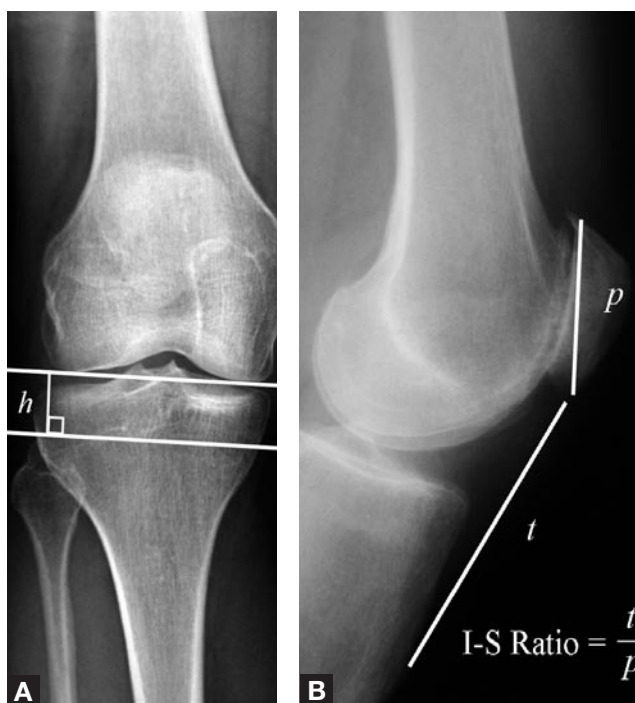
(A) Standing anteroposterior x-ray shows joint-line height measured as perpendicular distance between a line connecting the distal points of the femoral condyles and the proximal tip of the fibular head. (B) Insall-Salvati ratios were determined from lateral x-rays with a knee flexion angle of 20°.
